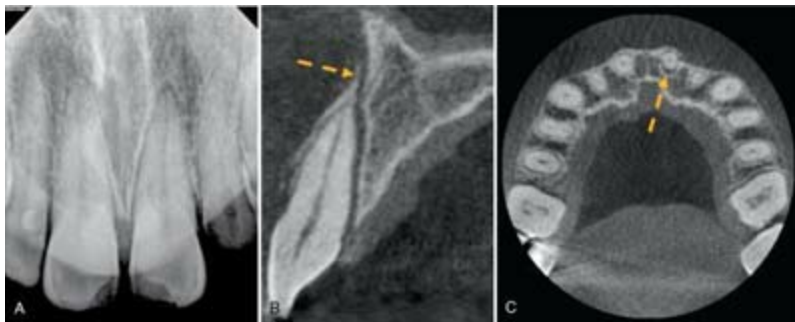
After a traumatic injury to the maxillary right and left central incisors, crown fractures were noted. The PA radiograph showed an extrusive luxation injury in the maxillary left central incisor (A). The alveolar fracture (B, *yellow arrow*) and true extent of the displacement (C, *yellow arrow*) became evident with CBCT.
